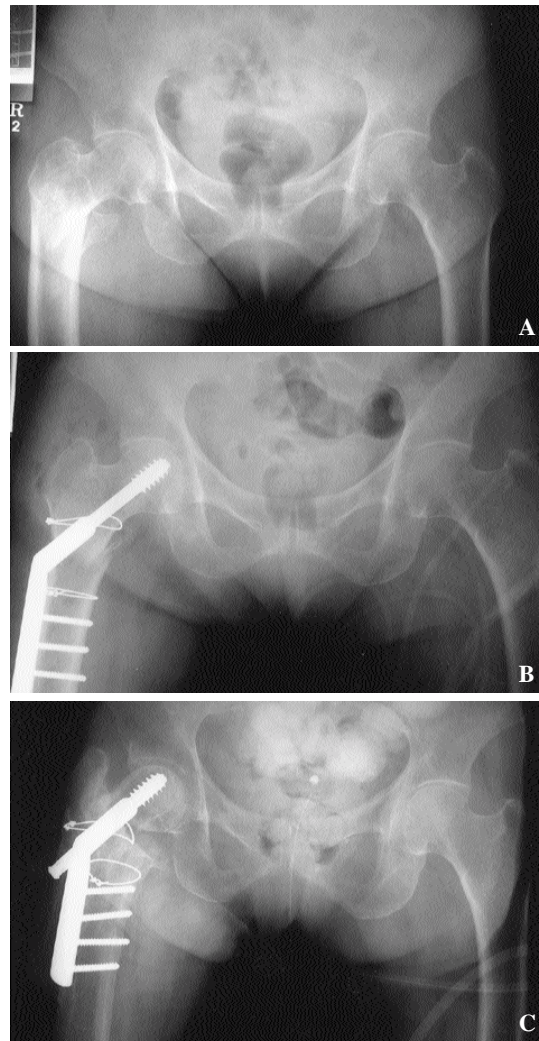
Serial radiograph of 74 year old woman treated by a compression hip screw. A. Evans unstable intertrochanteric fracture. Preoperative radiograph. B. Immediate postoperative radiograph. C. Postoperative 1 year radiograph showed nonunion.
